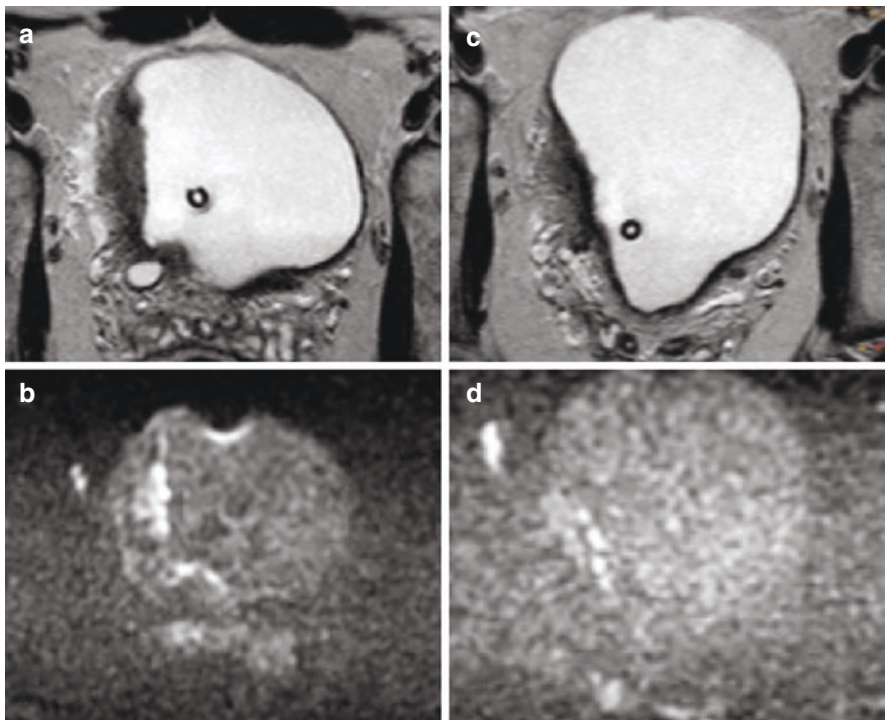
In baseline MR images (a–b), there is a plurinodular lesion, hypointense in T2 (a) and hyperintense in DWI in sequences with a high b-value. After treatment (c, d), there is a moderate size reduction of the lesions. Most visible micronodularities persist in DWI (d) sequences with high b-value. These features indicate a partial response to treatment
